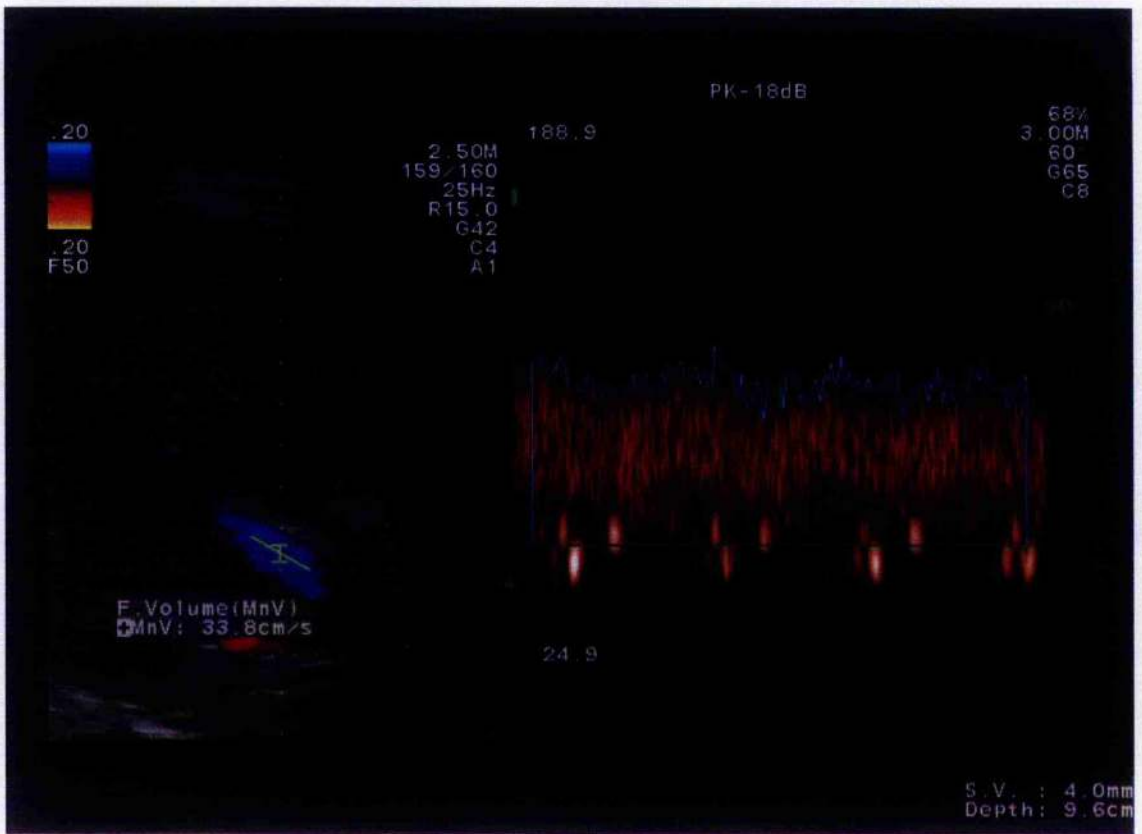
Figure F Colour Doppler ultrasound image and corresponding Doppler trace of portal vein. Example of time average mean velocity shown (F. Volume MnV : 33.8cm/s).
